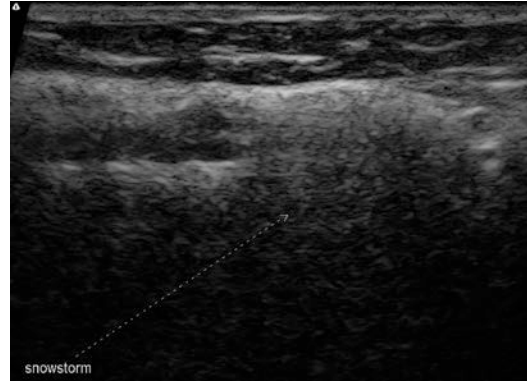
Grayscale ultrasound image of broken silicone gel breast implant exhibiting the snowstorm sign
